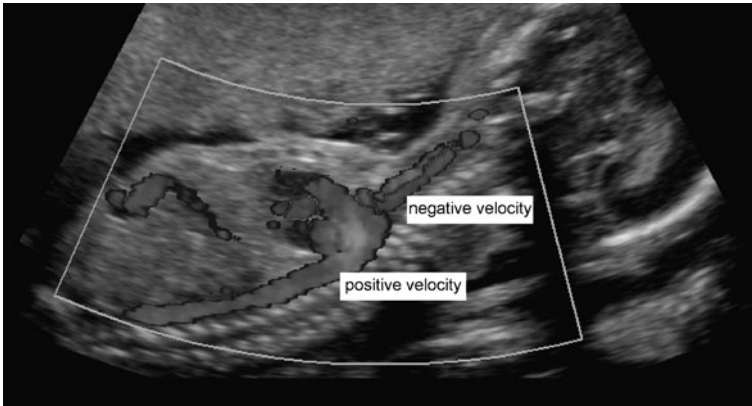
Doppler sonography uses the Doppler effect to depict blood velocity. In its original, velocity is color-coded differentiation between flow direction and velocity (image with kind permission of Siemens Sector Healthcare, Erlangen, Germany)
